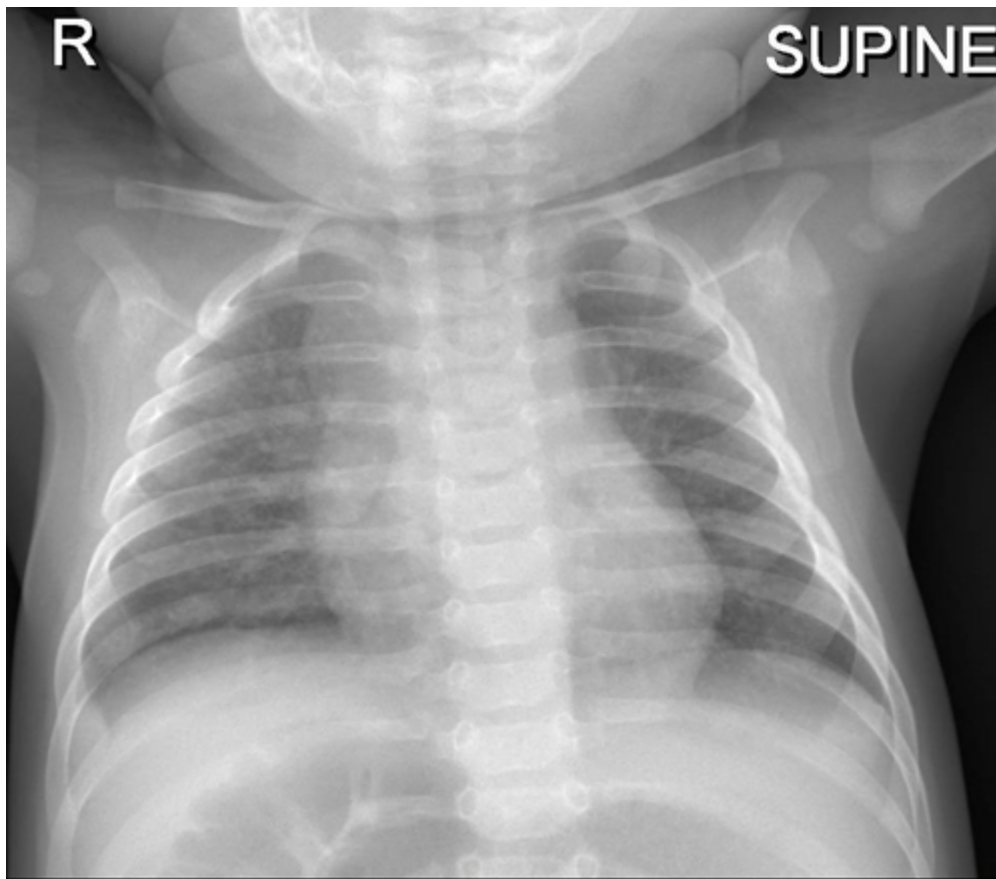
Chest X-ray showing right perihilar peribronchial thickening and airspace opacities, as well as reduced calibre of bilateral mainstem bronchi. ↩
